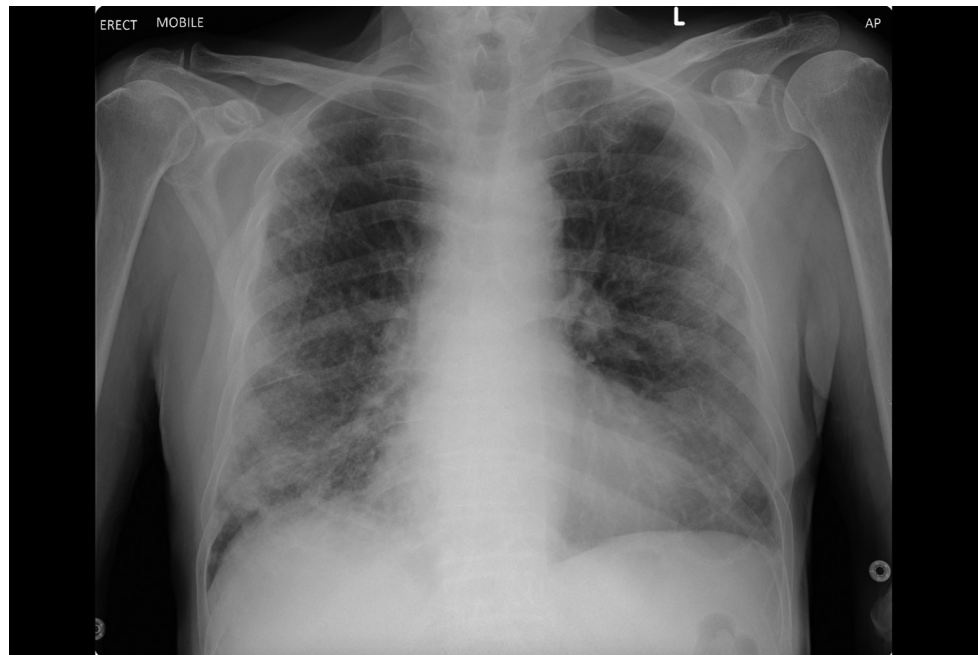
Chest radiograph taken on day 3 of admission.
